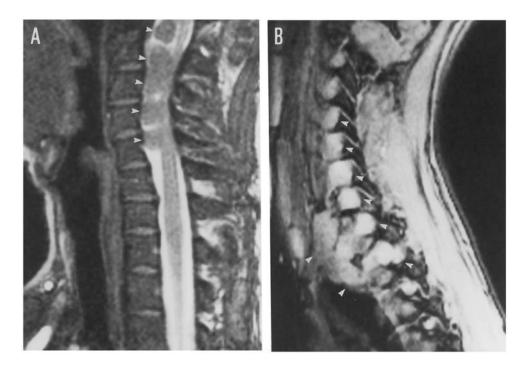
Sagittal T2-weighted spinal MRI scan of patients II-3 and III-2. *A*, Patient II-3: intradural and extramedullary neurofibromas (*arrowheads*), with compression of the cervical cord and enlargement of the cervical spinal canal. *B*, Patient III-3: multiple cervical and dorsal neurofibromas (*arrowheads*), with extension outward from the spinal canal through the intervertebral foramen.
